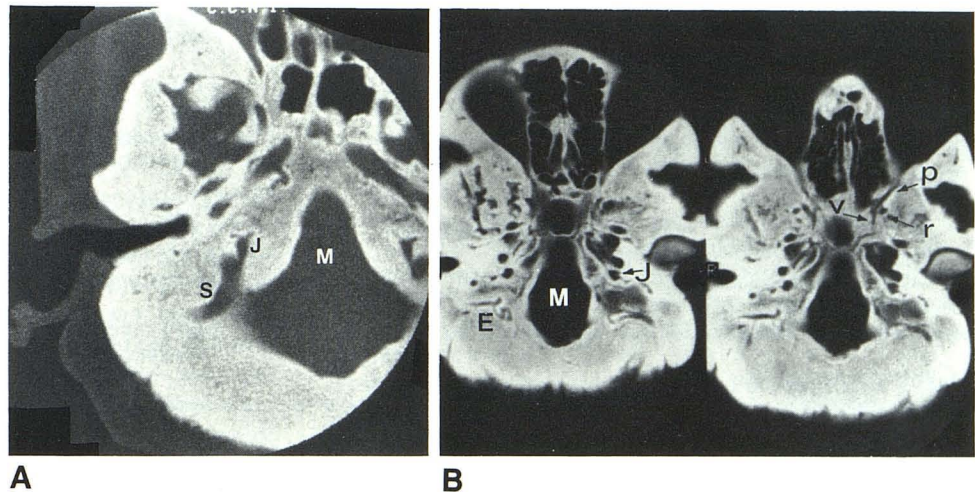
A, Axial CT scan shows small foramen magnum (M) with overgrowth of basiocciput and exocciput on each side resulting in narrowing of space for brain stem. Jugular bulb (J) is small with prominent groove of sigmoid sinus (S). B, Axial CT scans through skull base show small foramen magnum (M) and jugular canals (J) with evidence of venous collateral channels or emissary veins (E). Anterior portion of the vidian canal (V) with foramen rotundum (r) as well as pterygomaxillary fissure (p).
